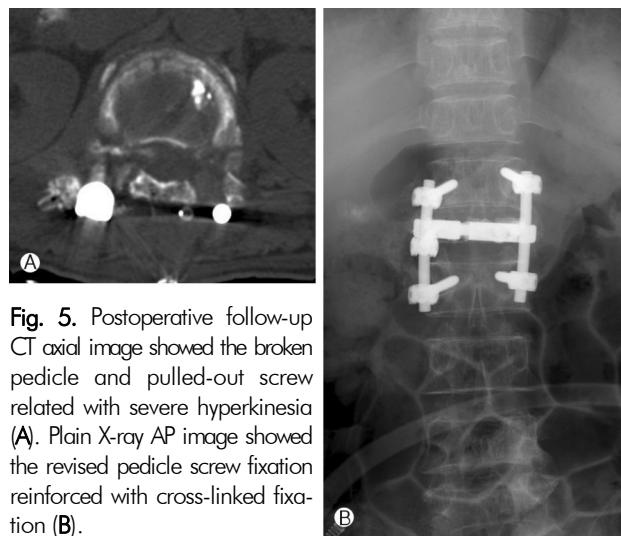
Postoperative follow-up CT axial image showed the broken pedicle and pulled-out screw related with severe hyperkinesia (A). Plain X-ray AP image showed the revised pedicle screw fixation reinforced with cross-linked fixation (B).
